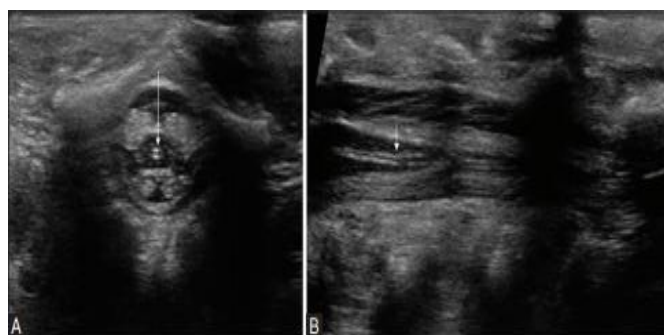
(A and B): Axial (A) Sagittal (B) sonogram of the distal conus medullaris and filum terminale revealing mild dilatation of the canal (arrow) in a healthy newborn
